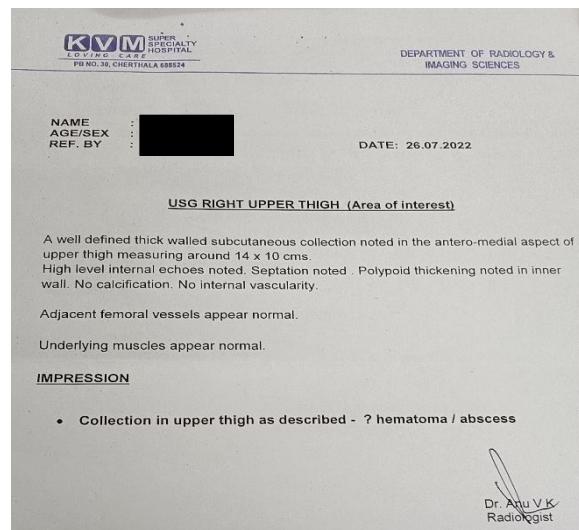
The ultrasonography report of the swelling.
